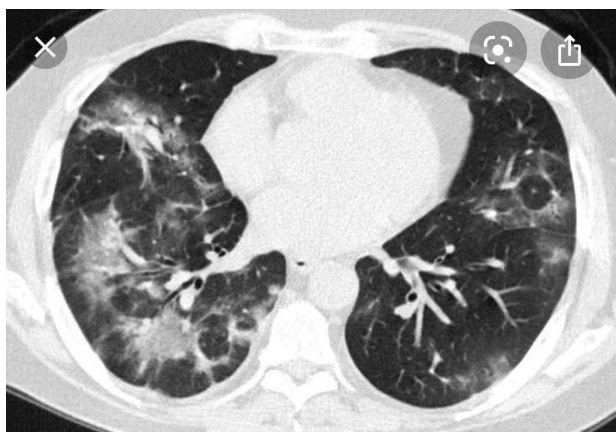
The spiral chest CT scan shows bilateral patchy infiltration.
